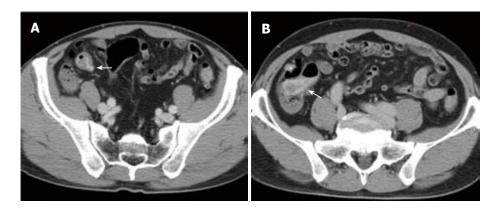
Contrast-enhanced computed tomography scans on admission. A: In the arterial phase, a diverticulum of the terminal ileum was seen and leakage of the contrast medium into the ileal lumen around the diverticulum was also visualized (arrow); B: In the venous phase, the contrast medium spread to the ileocecal valve (arrow).
